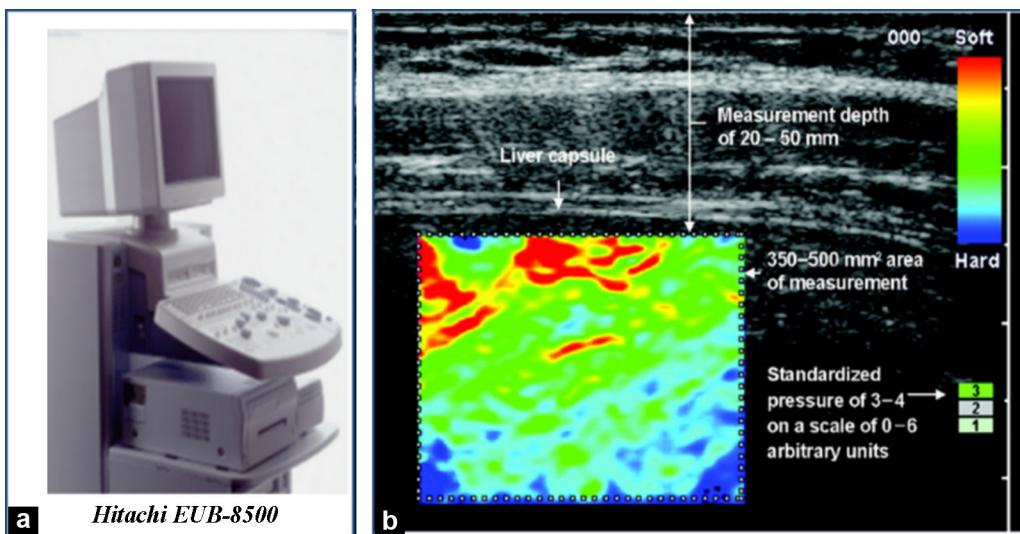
Standard elastography: Hi-RTE: a: ultrasound; b: example of measurement [58].
